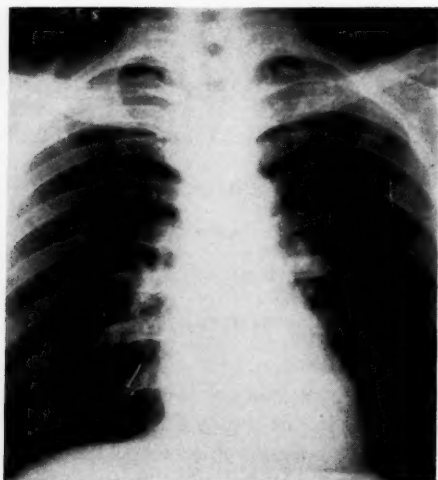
Postero-anterior roentgenogram showing an escutcheon nail in the posterior basal segment of the right lower lobe bronchus.
